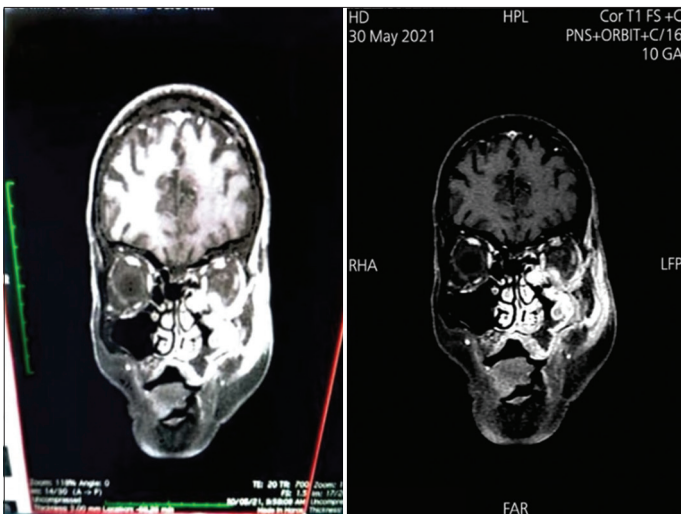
MRI showing fungal invasion of the left maxillary and ethmoidal sinuses with extension into the left orbit, left masticator space, and infratemporal fossa with bony erosion of the left maxilla, left zygomatic bone, and left half of hard palate. MRI taken on day 1 (left) and day 21 (right)
